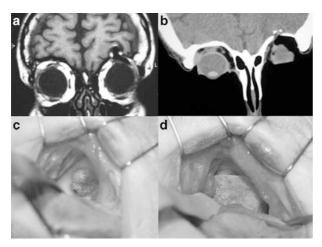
(a) T2-weighted coronal MRI scan showing herniation of intraorbital tissue into anterior cranial fossa. (b) CT scan revealing breach in orbital roof. (c) Intraoperative picture showing bony defect in its entirety. (d) Intraoperative picture showing Medpor placed over bony defect.
